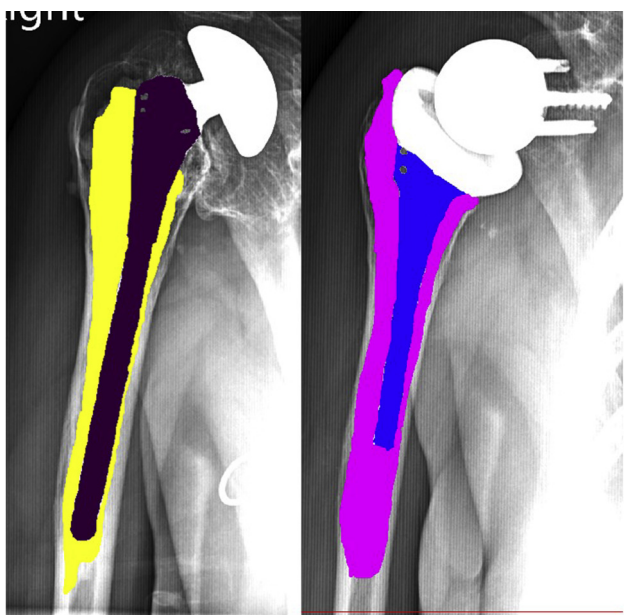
Preoperative and postoperative radiographs of the patient shown in [Figure 1](#) with quantified areas of stem and cement mantle. *Yellow*, preoperative area of cement; *Purple*, preoperative area of stem; *Pink*, postoperative area of cement; *Blue*, postoperative area of stem.
